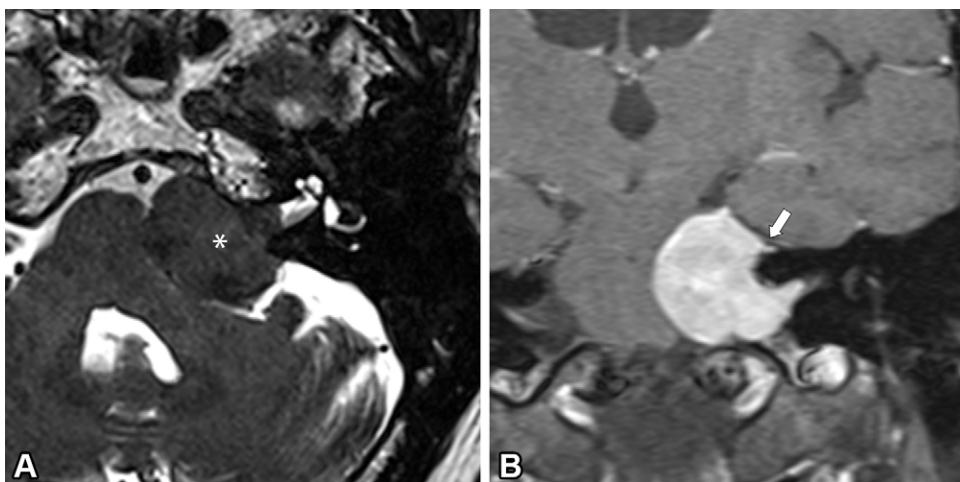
Cerebellopontine angle meningioma in a 66-year-old patient with left-sided pulsatile tinnitus and hearing loss. (A) Axial image from 3D T2-weighted sampling perfection with application-optimized contrast using different flip angle evolution (SPACE) MRI shows a large mass (*) at the left cerebellopontine angle protruding into the IAC. (B) Coronal postcontrast T1-weighted image shows avid enhancement of the lesion with a dural tail (arrow). The patient underwent resection; results of pathologic analysis were consistent with a meningioma.
